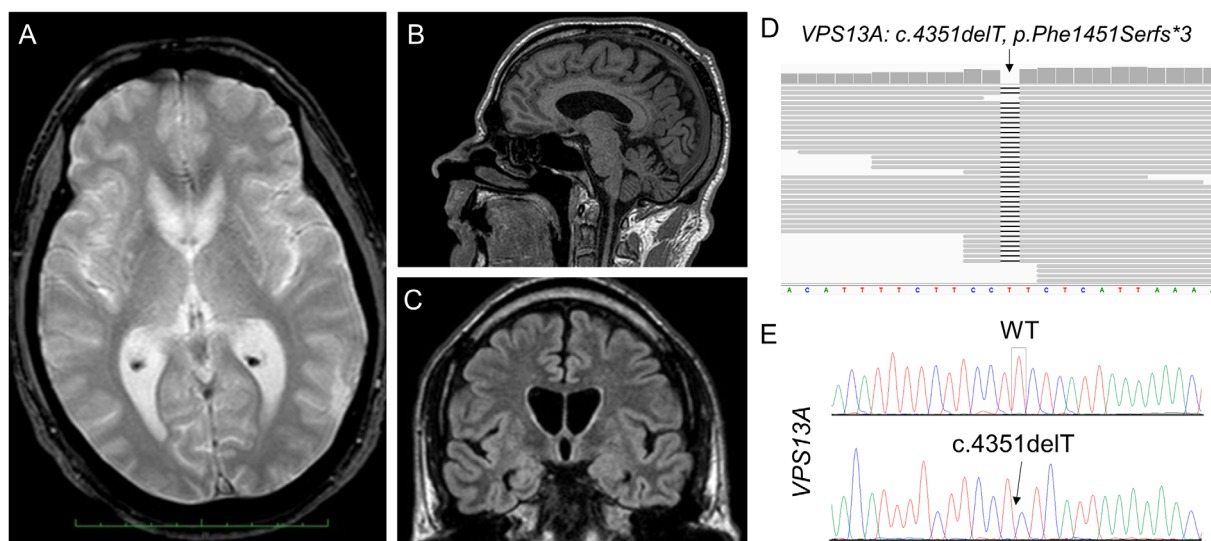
(A–C) Brain MRI of the patient performed at age 48: axial T₂-weighted sequence showing symmetrical hyperintensity surrounding the putamen and mild generalized atrophy (A), sagittal T₁-weighted sequence showing moderate atrophy of the cerebellar vermis (B), coronal FLAIR sequence revealing symmetrical atrophy of the caudate nucleus (C, D) IGV viewer snapshot of genomic .bam file demonstrating the homozygous deletion of a single thymidine (T) in position c.4351 of the *VPS13A* gene; (E) Sanger validation of the identified homozygous *VPS13A* single base deletion: wild-type (WT) in the upper panel and proband's variant in the lower panel.
